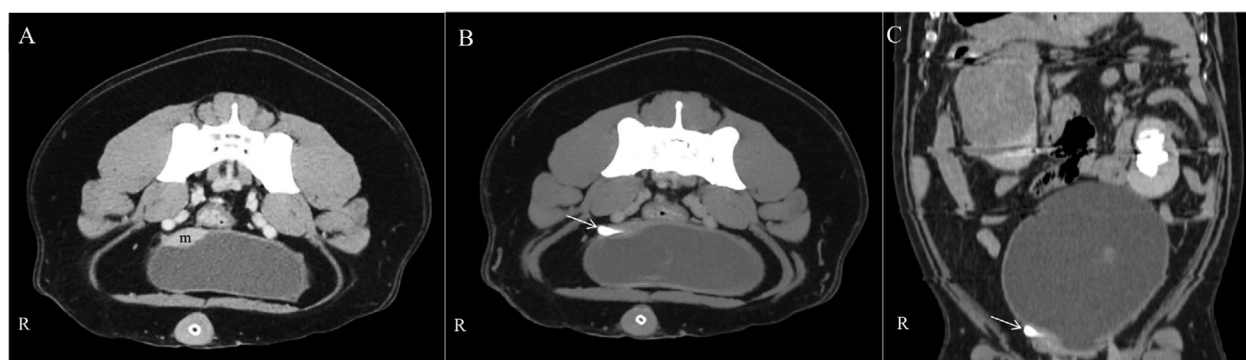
Computed tomographic images. Transverse views (A and B) and dorsal reconstruction view (C) of the urinary bladder. A mass (m) arising from the right dorsal bladder wall at the level of the bladder trigone was observed (A). Note the right ureter with contrast ending in the bladder mass (arrow) (B and C)
